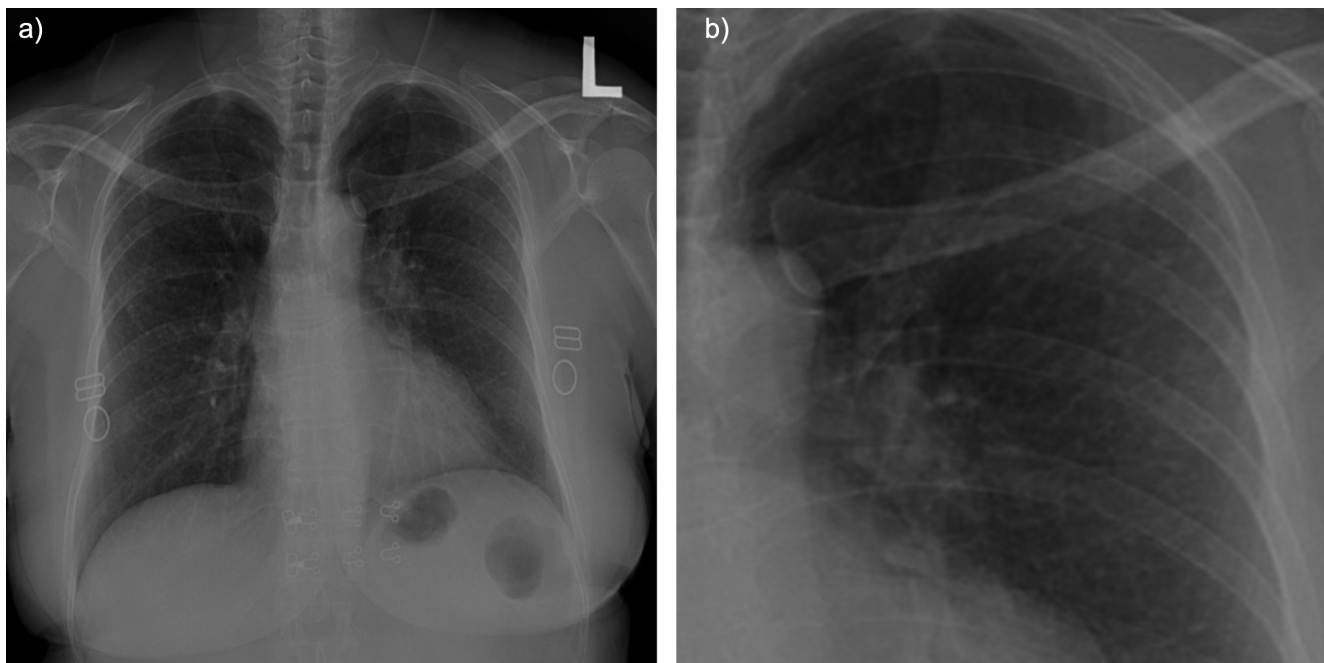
Patient #1. a) Chest radiograph (posteroanterior) showing a profusion of q/q 3/2. b) Magnification of the chest radiograph. Adapted from Stitsmith *et al.*, BKK Med J 2021;17:142-5, with permission.
